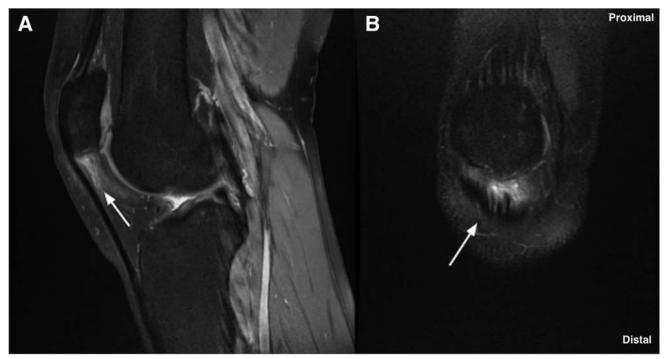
Preoperative magnetic resonance imaging (MRI) of a sagittal (A) and coronal (B) view of the right knee. An MRI scan should be performed to assess the severity and location of separation of the patellar tendon (white arrow) from the distal pole of the patella to ensure complete debridement of the degenerative tissue intraoperatively.
